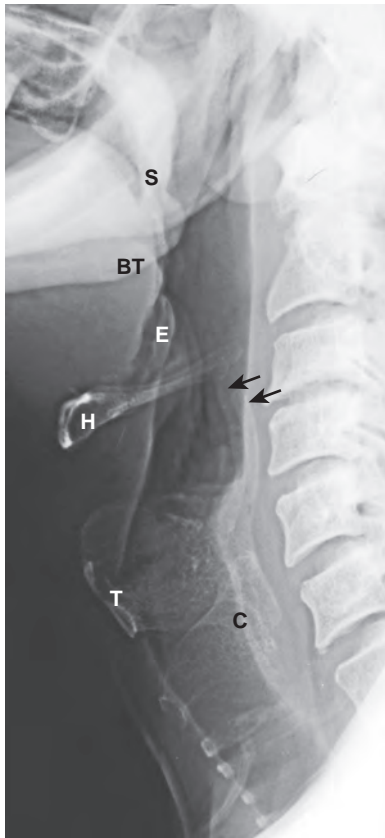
Laryngeal cartilages. Plain radiograph with patient in a lateral position shows the hyoid bone (H), tip of the epiglottis (E), calcified thyroid cartilage (T), calcified superior cornu of the thyroid cartilage (arrows), and calcified cricoid cartilage (C). The soft palate (S) and base of tongue (BT) are identified. The lower hypopharynx is devoid of air. A small amount of air is seen in the laryngeal ventricle. Note the normal width of the soft tissue posterior to the pharyngeal air column.
